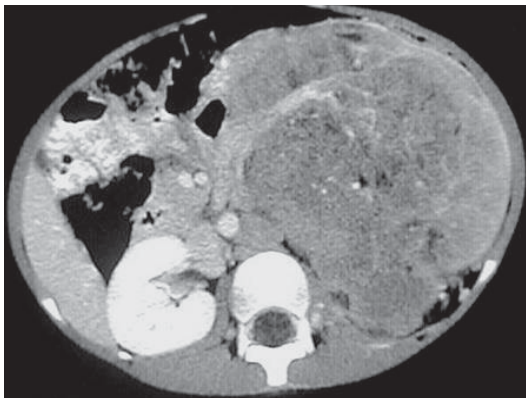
Computed tomography. Nephroblastoma. Large neoplasm arising from the kidney occupies the entire left hemi-abdomen
